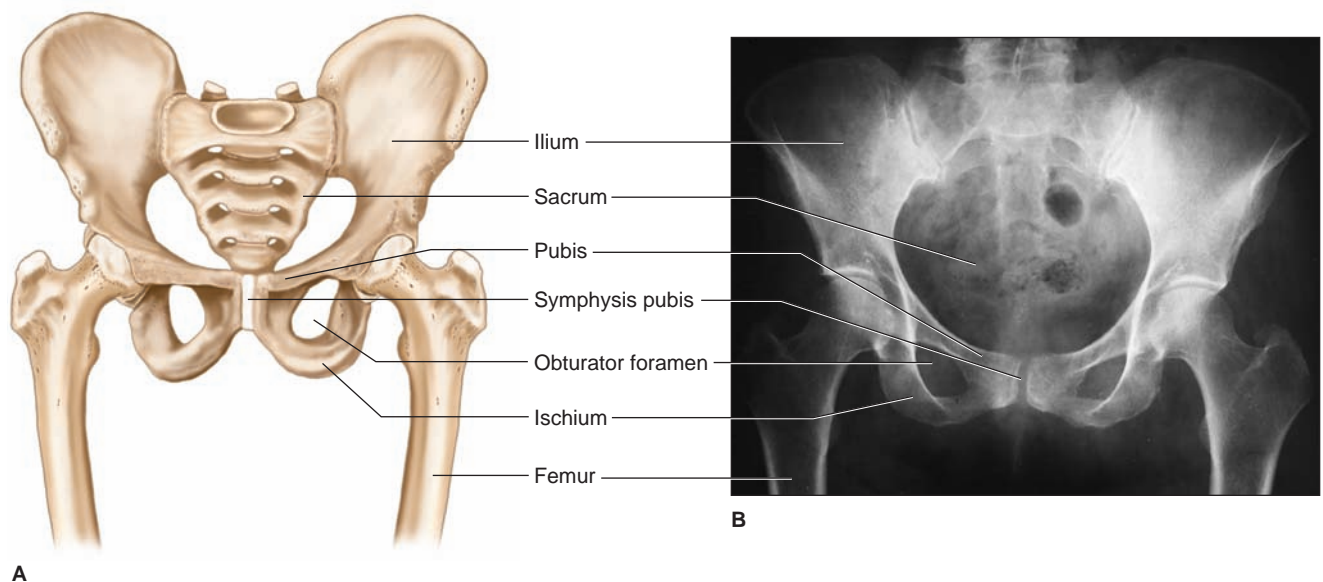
(a) Pelvic girdle. (b) Radiograph of the pelvic girdle.
